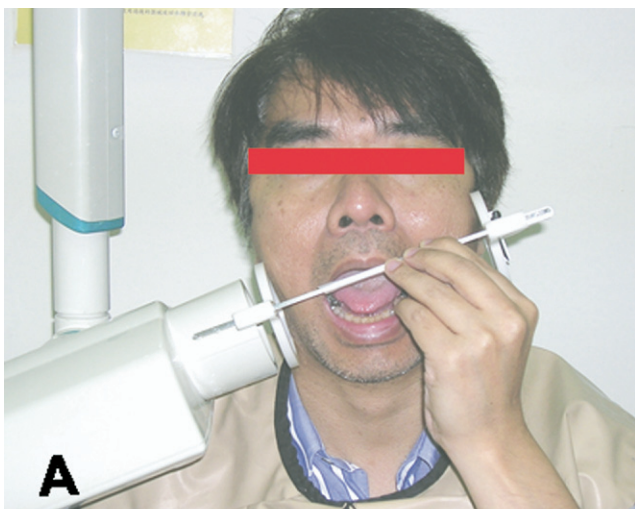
A representative demonstration of taking a radiograph of the left upper third molar area using the extraoral radiographic technique and employing the aiming device (A). The image acquired is shown in B; the left upper second and third molars are indicated. Note that an implant is placed at the original left upper first molar position. (The radiopaque small letter “a” is equivalent to the dot mark on conventional film).
